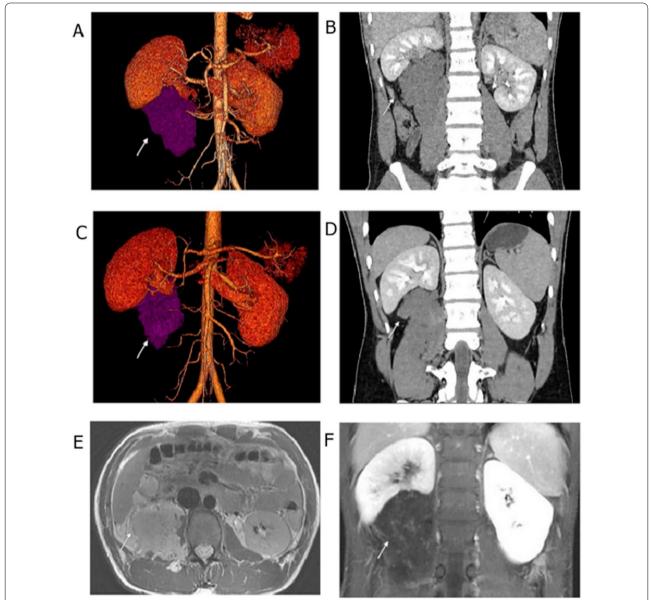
A–D A large soft tissue dense mass (white arrow) was seen below the right kidney of the retroperitoneum on CT images, with an ill-defined boundary with the psoas major muscle. No definite enhancement was observed after iodine contrast injection. E MRI T1WI showed hyperintense signal mass with ill-defined boundary with psoas major muscle and flowing void effect was revealed in the tumor. F After gadolinium injection, cluster and speckled enhanced focal shadows were observed in the mass on coronal MRI
